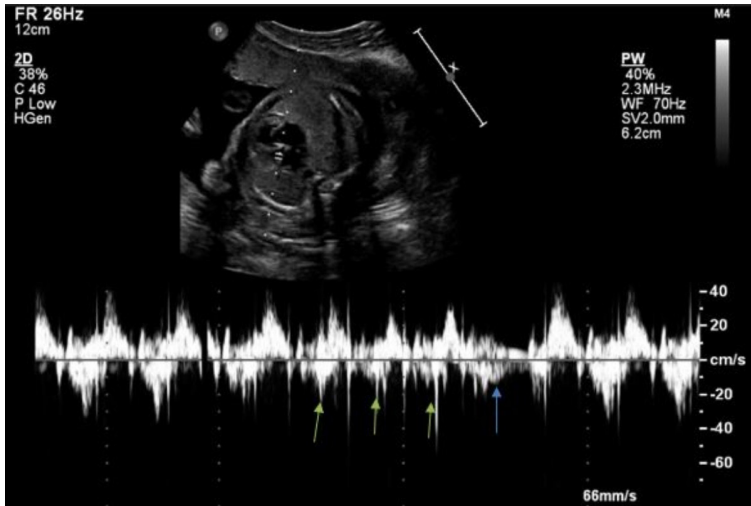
Mitral inflow/outflow Doppler showing a three-beat run of atrial tachycardia (AT) (green arrow) followed by a blocked premature atrial contraction (blue arrow).
